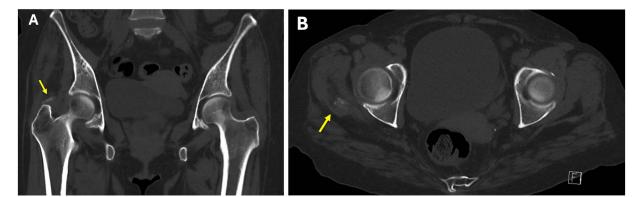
A 52-year old female with hydroxyapatite deposition disorder. FINDINGS: A small area of poorly defined calcification at site of right gluteus medius insertion into right greater trochanter (arrows). TECHNIQUE: A Non-contrast computed tomography coronal (a) and axial (b) images of the pelvis
